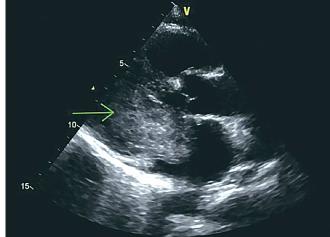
Transthoracic echocardiography (long axis view) showed severe prolapse of left atrial myxoma (an arrow) into the left ventricle in a 56-year-old patient with fever of unknown origin [41]
